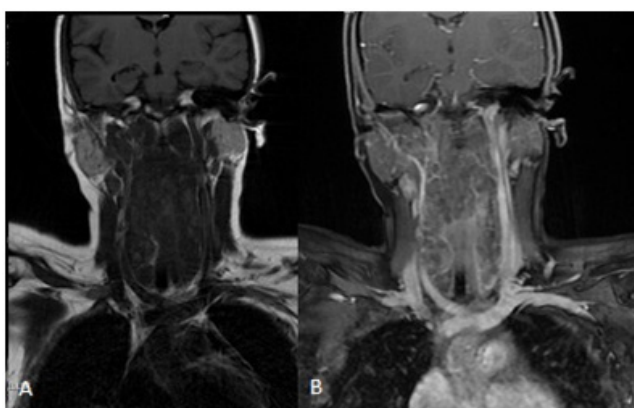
Preoperative T1W1 MRI of retropharyngeal mass. The lesion was seen hypointense to isointense in comparison to adjacent muscles. A: Without contrast, B: With GAD IV contrast.
